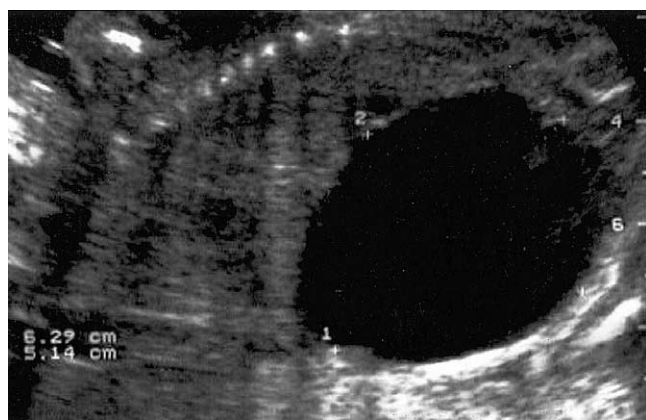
Large fetal bladder seen on a longitudinal view of abdominal ultrasound at 22 weeks gestation. The fetus is in prone position.
